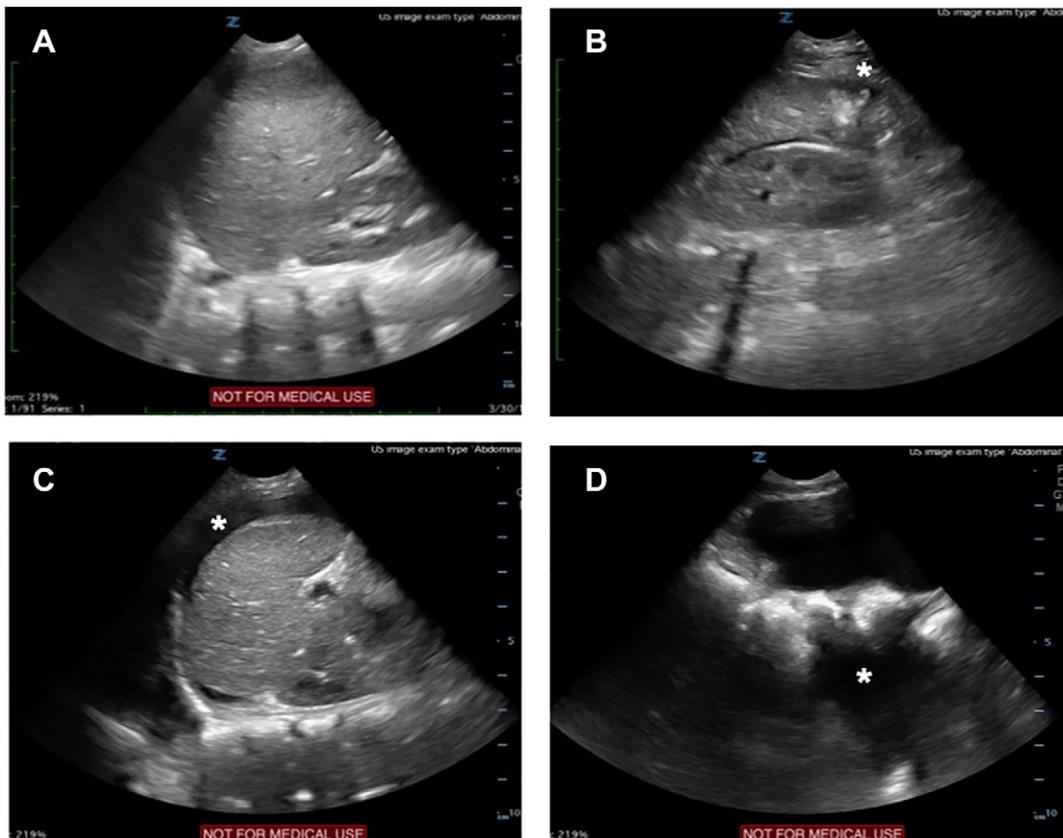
Point-of-care ultrasound images of the abdomen. A, Right upper quadrant (RUQ) no significant free fluid in first image of RUQ (limited view of Morison's pouch, liver tip not visualized). B, RUQ at liver edge showing accumulation of free fluid at tip of liver and in Morison's pouch. C, Left upper quadrant free fluid in a circumferential pattern around the spleen. D, Pelvic free fluid adjacent to the bladder.
